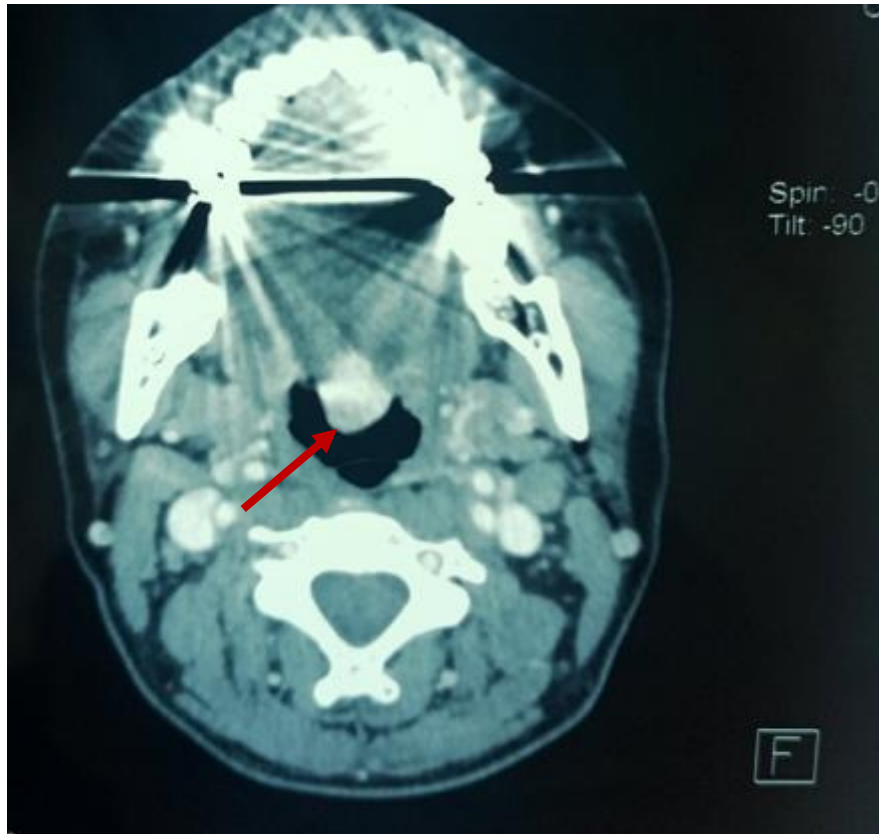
Contrast-enhanced computed tomography (CT) scan of neck showing a well-defined homogenous enhancing nodule in the midline of the base of the tongue measuring 19 x 15 x 19 mm
